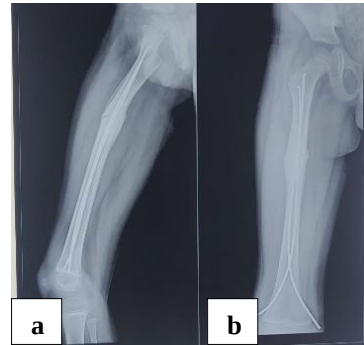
(a and b): Pre-op X-ray showing fracture shaft femur (R) (proximal 1/3rd- distal 2/3rd junction) in a 6-year-old female.
